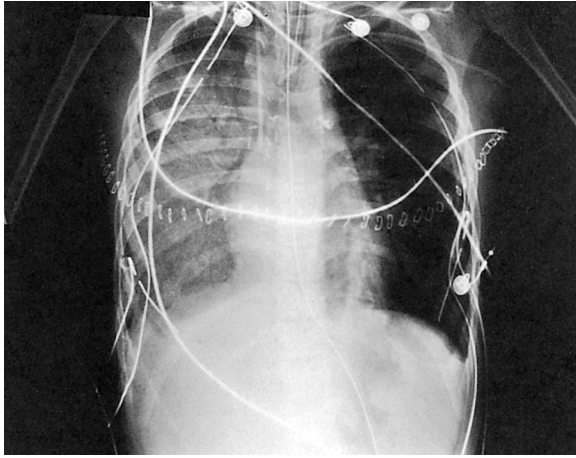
This chest radiograph demonstrates reperfusion injury to the right lung immediately after double-lung transplantation in an 11-year-old girl with cystic fibrosis. There is a ground-glass haziness with air bronchograms over the right lung field. The staples across the chest are external and used for surgical skin closure. There are surgical clips in each hilar region where the vascular anastomoses were performed. There is also an endotracheal tube, a nasogastric tube, a left subclavian vein catheter, a right internal jugular vein catheter, bilateral chest tubes, and surface electrodes. (From Moodie DS, Stillwell PC: Thoracic organ transplantation in children: the state of heart, heart-lung, and lung transplantation. *Clin Pediatr* 32:322–328, 1993.)
